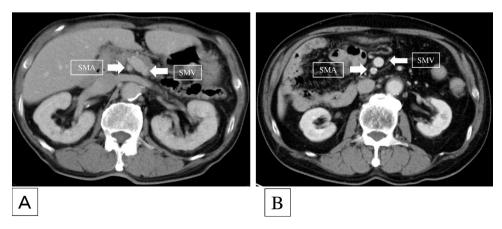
(A, B) Abdominal enhanced computed tomography showed that the superior mesenteric vein (SMV) was located on the left side of the superior mesenteric artery (SMA) (SMV rotation sign) in both cases.
